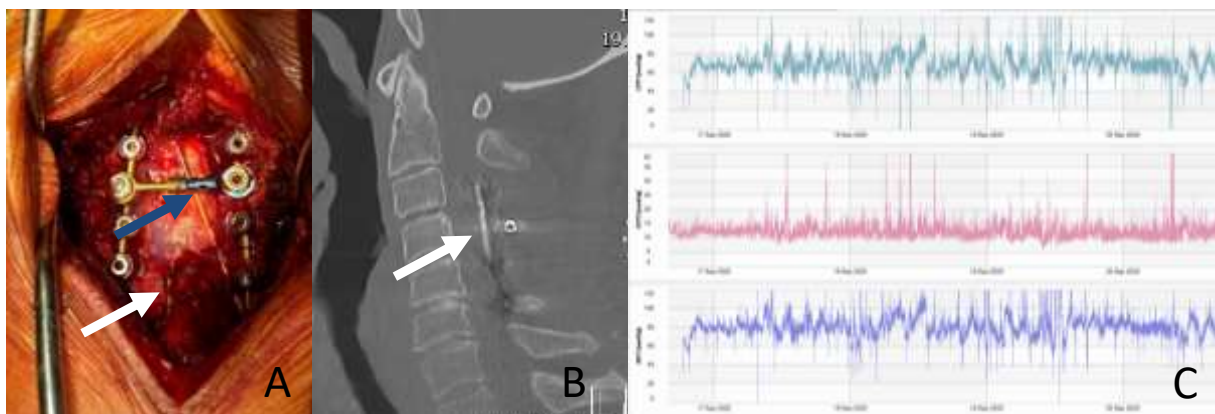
ISP monitoring in a patient with cervical spinal cord injury and posterior decompression and fusion. A: Intraoperative picture of epidural (blue arrow) and intradural probe (white arrow); B: CT showing intradural probe (white arrow); C: Recordings of SCPP, ISP and MAP (ICP =ISP, CPP=SCPP, ART= MAP).
